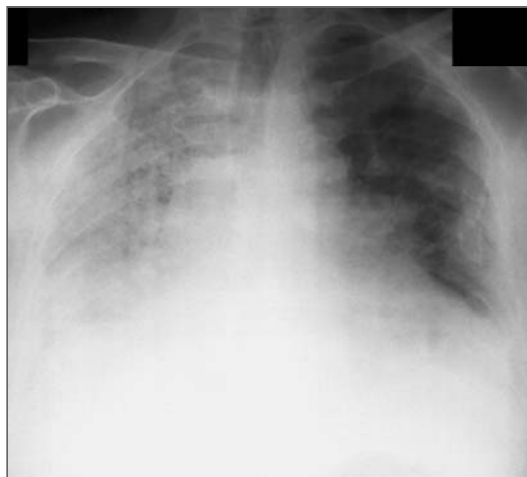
Chest Radiograph Obtained during the Third Admission.
